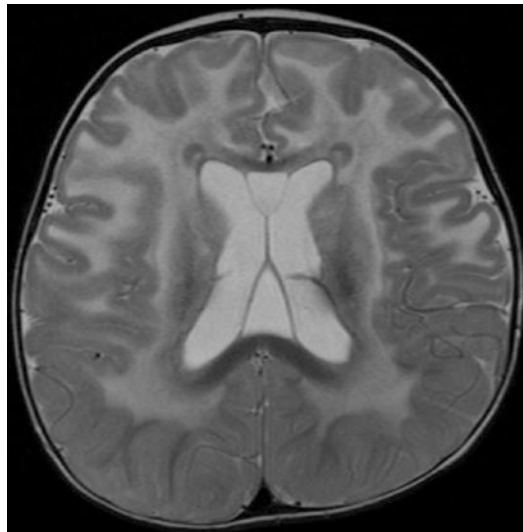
T2-MRI: frontally accentuated leukodystrophy and macrocephaly in GFAP-mutated Alexander disease
